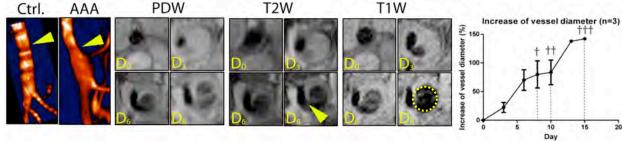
Time of flight angiography and multi-contrast MRI of AAA temporal progression. Arrows point to a medial rupture with blood infiltrating the adventitial tissue. The increase in diameter of the aorta over a 15 days period is reported on the graph.
